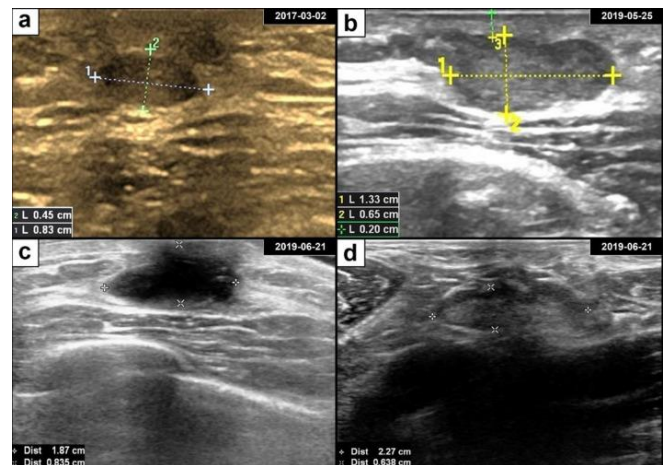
Breast adenoid cystic carcinoma ultrasound and postoperative findings. (a) Ultrasonography revealed a well-defined oval hypoechoic mass in the retroareolar region of the left breast. (b) The subareolar mass progressively enlarged over the course of 2 years. (c) Ultrasonography showed a hypoechoic area after lumpectomy. (d) Ultrasonography of an enlarged axillary lymph node with a clear boundary. Image source: Li et al. (4) doi: 10.14740/jmc3790; reused under the terms of the Creative Commons Attribution Non-Commercial 4.0 International License.
